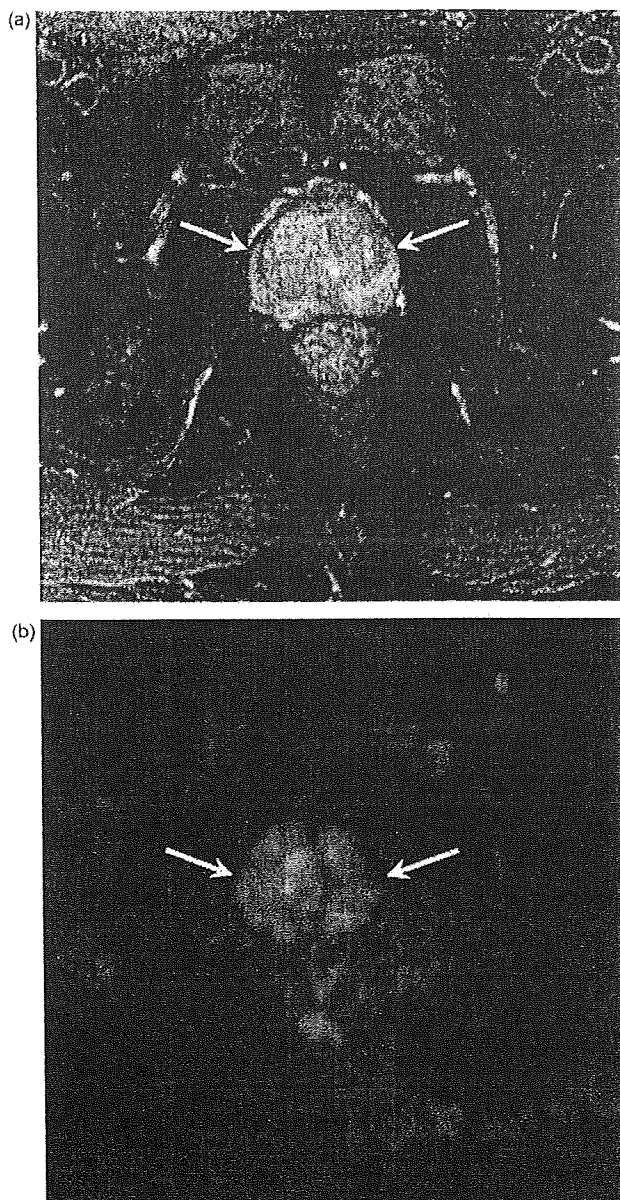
Prostatic lesions in a 66-year-old man (same case as in Fig. 9a). (a) Axial T2-weighted image with fat saturation shows prostate swelling (white arrows). No mass lesions can be detected. (b) Diffusion-weighted image shows diffuse high intensity signal in the prostate (white arrows).
